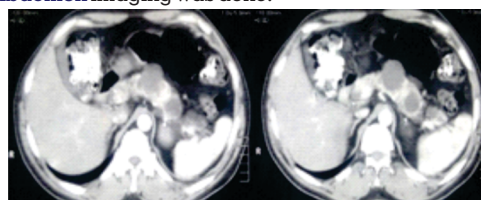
CT Abdomen with Pancreatic Cysts.
